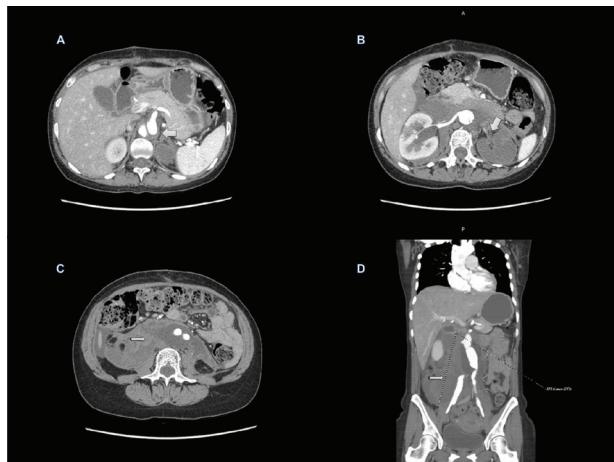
Contrast enhanced abdominal computed tomography scan (two days after the surgery). A, B and C (axial views): A) Dissection of the abdominal aorta (big arrow). B) Thrombosis of the left renal artery (big arrow). C and D (coronal view): Large retroperitoneal hematoma (small arrow).
